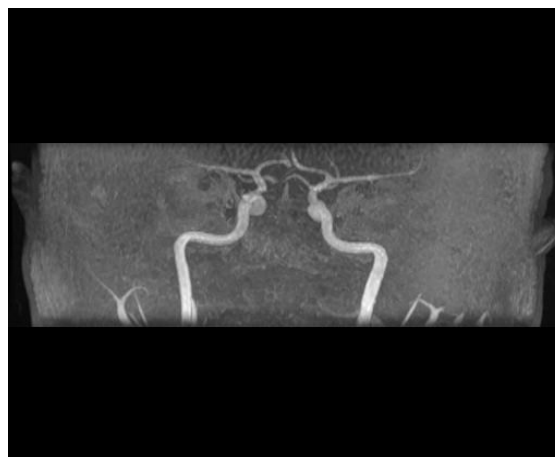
MRI angiography: complete thrombosis of the basilar trunk
